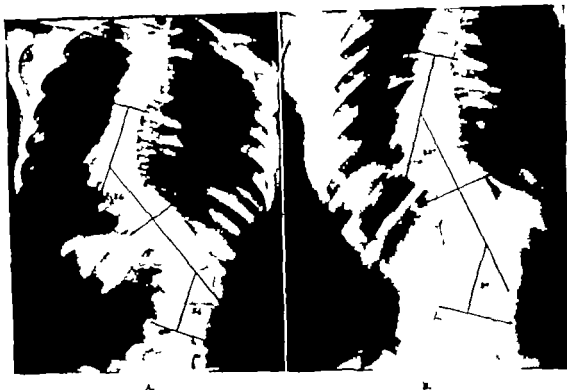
A, This roentgenogram shows a double primary curv with patient in the standing position before fusion. Rotation of L4 would place it within the lower primary curve; however the shortness of the lower fractional curve, situated between a curve of great magnitude above and the sacrum below has forced L4 to rotate beyond the neutral. L3 reveals maximum tilting. The intervertebral space above L3 is wider on the convex side of the curve, and the intervertebral space below L3 reveals no wedging, both indicating that L3 is in this case the terminal of the lower primary curve rather than L4 which has been forced to rotate. B, Roentgenogram showing the double primary curve corrected and fused. (From Schmidt, A. C. Verhandl. deutsch. orthop. Gesellsch. 41 Kongress, pp 195-220 1934 Ferdinand Enk Verlag Stuttgart.)
